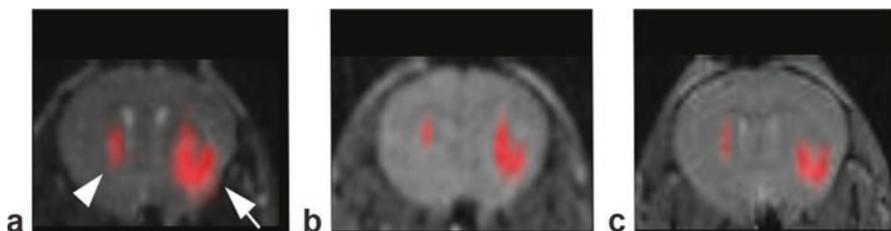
In vivo ^{19}F MRI of transplanted NSCs pre-labeled with cationic perfluoro-15-crown-5-ether, with the ^{19}F signal superimposed on the ^1H MR images. MR images were acquired at 1 h (a), 3 days (b), and 7 days (c) after injection of 4×10^4 (left hemisphere, arrowhead in a) or 3×10^5 (right hemisphere, arrow in a) C17.2 neural stem cells. Reproduced, with permission, from [108]
